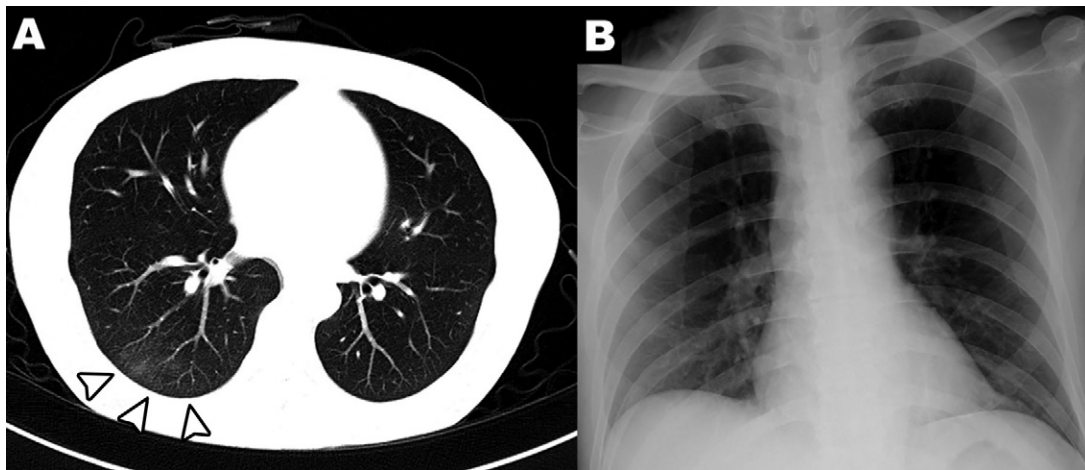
Images in a 43-year-old male patient with coronavirus disease 2019. Ground-glass opacities were observed at, A, CT (arrowheads) but they were not observed on, B, a chest radiograph.
